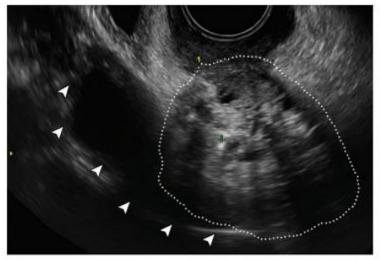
Vaginal forniceal lesion as visualized using 2D (A) and 3D (B) ultrasound in the same patient with extension toward the anterior rectal muscularis.
